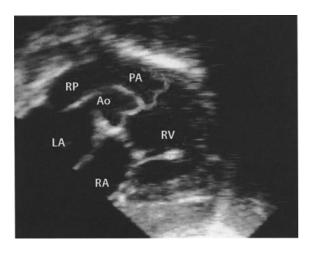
Double outlet right ventricle: echocardiography in the right oblique subxiphoid view showing a double outlet right ventricle with doubly committed ventricular septal defect (*Ao* aorta, *LA* left atrium, *PA* pulmonary artery, *RA* right atrium, *RPA* right pulmonary artery, *RV* right ventricle) (photograph courtesy of Dr. Michael Rigby)
